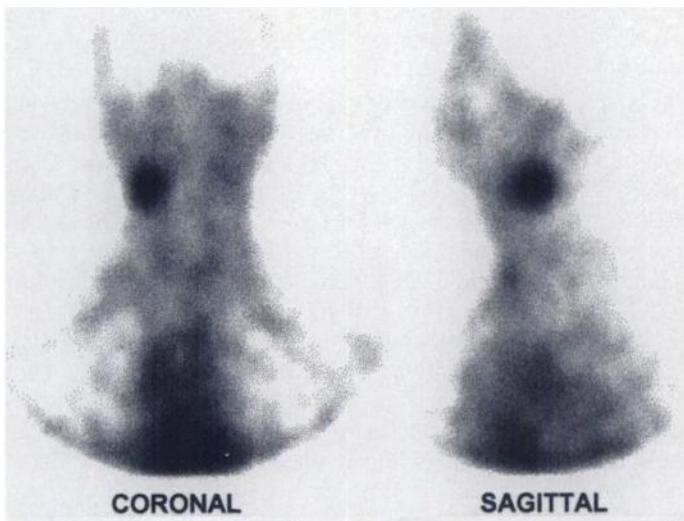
SPECT of neck and thorax of Patient 14 who had no tumor site known before IS. The coronal and sagittal views show highly contrasted spot in right upper neck.
